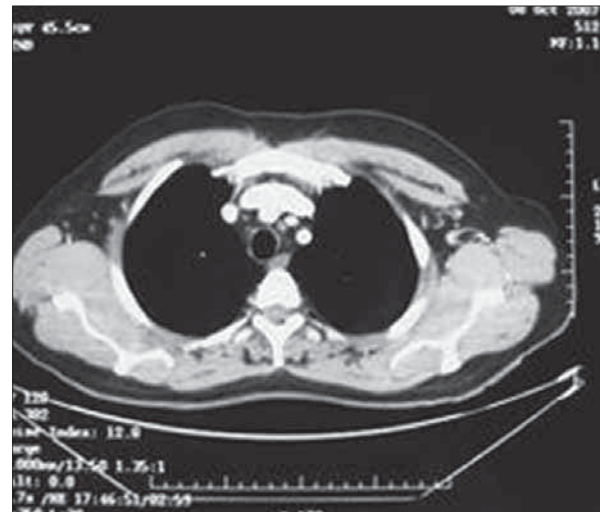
The second month postoperative control computed tomography of chest
